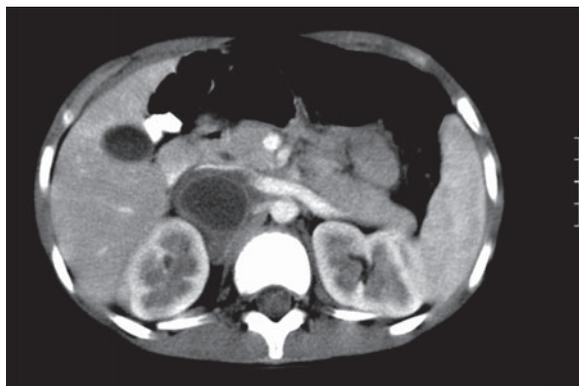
Girl WE. Abdominal CT study after contrast medium administration. Hypodense, cystic, peripherally enhancing tumor situated in the right paravertebral region.
